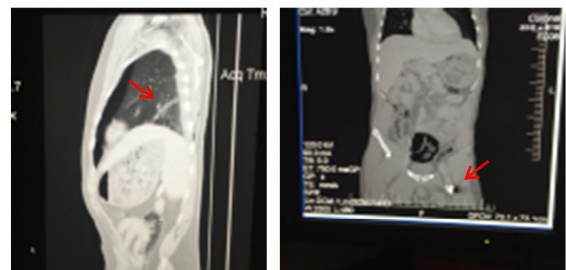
CT Scan of the chest, abdomen, and pelvis showing gunshot tract (left, red arrow) and a metallic bullet in the left inguinal region (right, red arrow).
